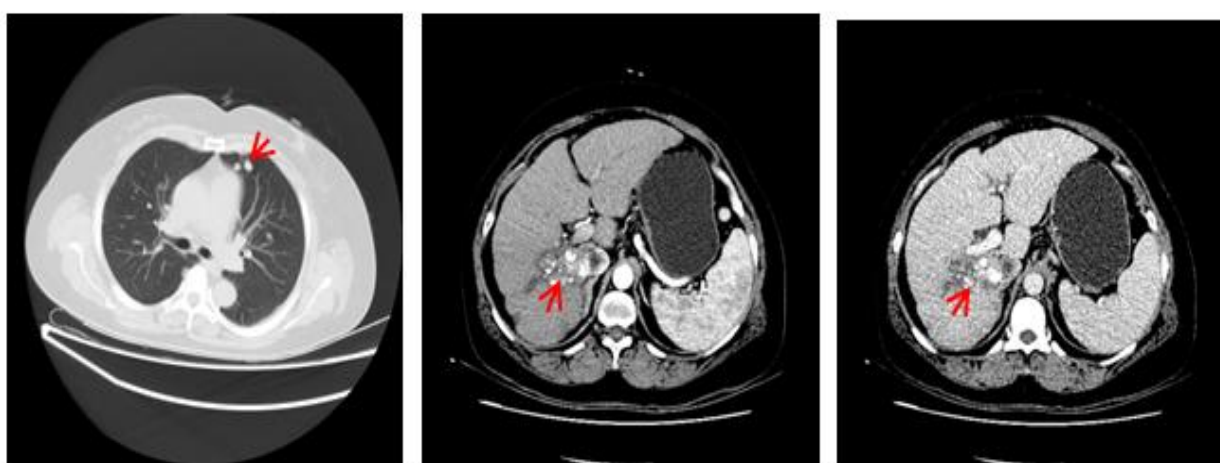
CT Findings After Two Cycles of the Quadruple Immunotherapy-Targeted Therapy Regimen Combined with TACE
